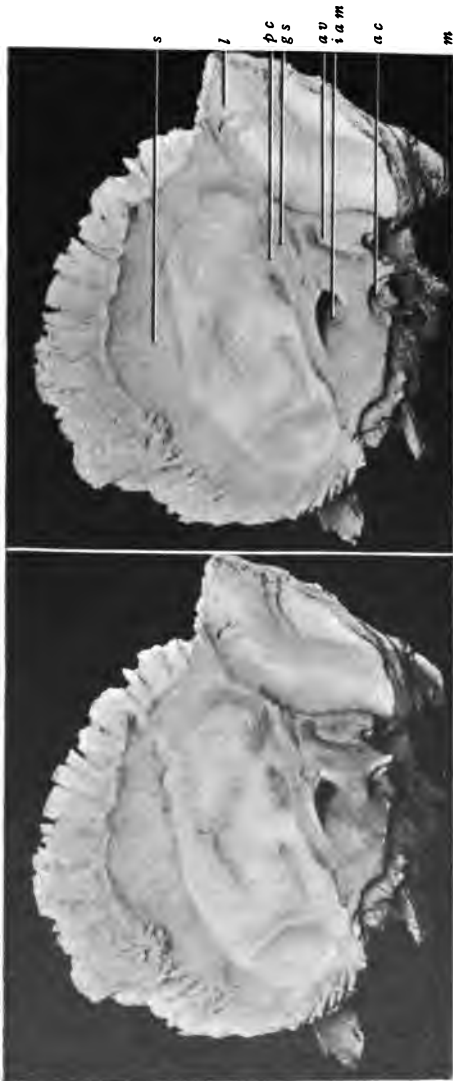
TEMPORAL BONE : VIEWED FROM THE INNER ASPECT. $\times \frac{1}{2}$.
